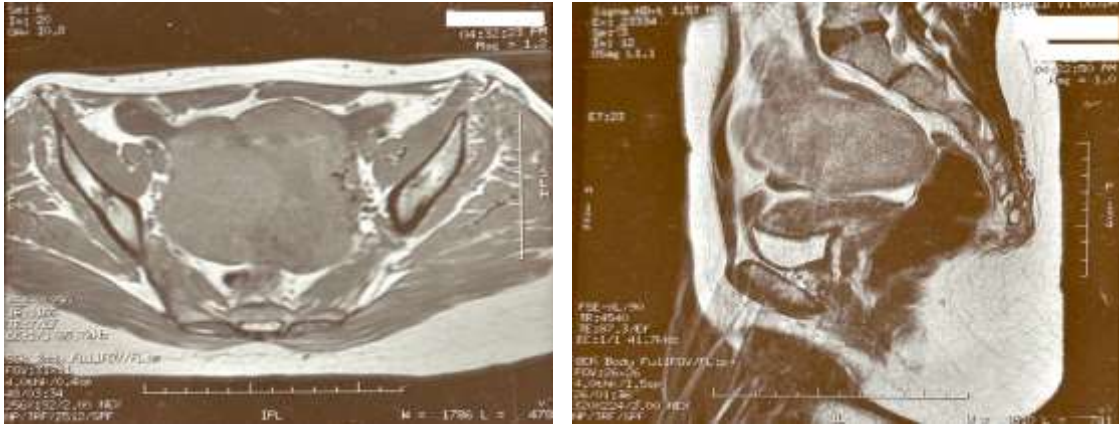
Dysgerminoma: pelvic MRI reveals a large solid-cystic mass.
